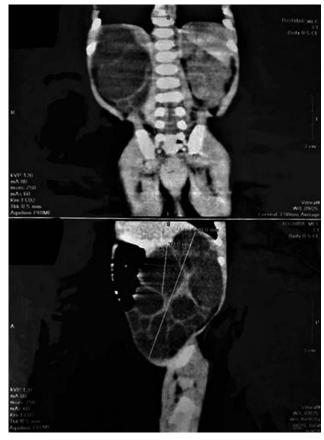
Coronal and sagittal sections computed tomography images showing the large multicystic kidney.
